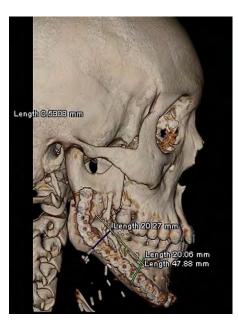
Three-dimensional CT with measurements of the mandibular defect.
